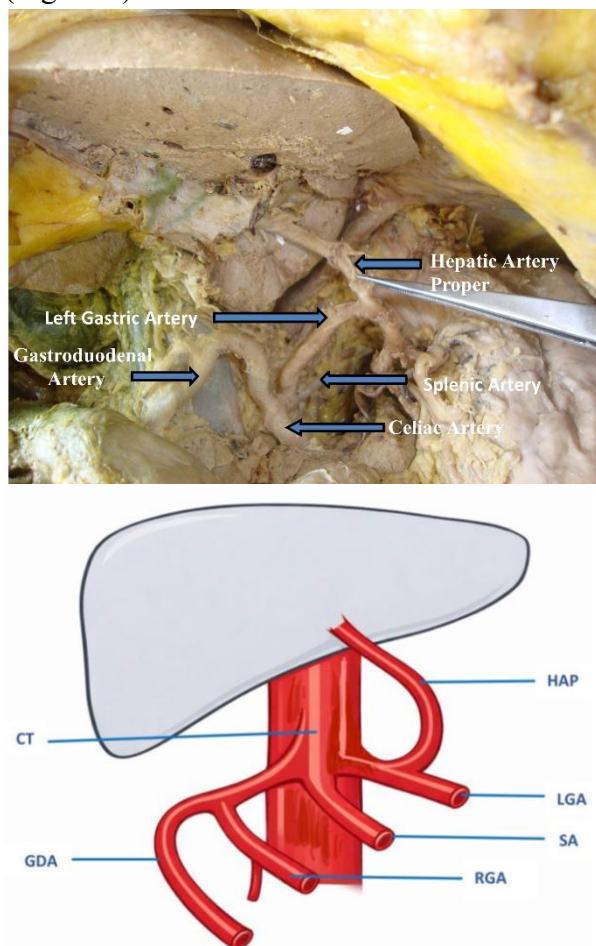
Anatomical variation showing the absent common hepatic artery and a proper hepatic artery arising from the left gastric artery. Top figure shows a photograph with a graphical representation given below it. CT-coeliac trunk, HAP -hepatic artery proper, LGA – left gastric artery, SA – splenic artery, right gastric artery, RGA – right gastric artery, GDA – gastroduodenal artery
